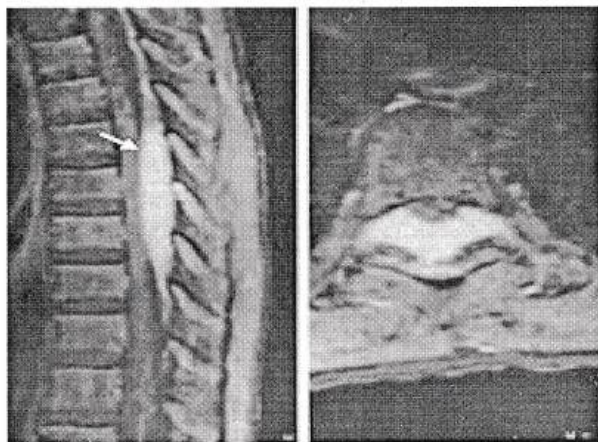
Post contrast MRI of spinal meningioma
